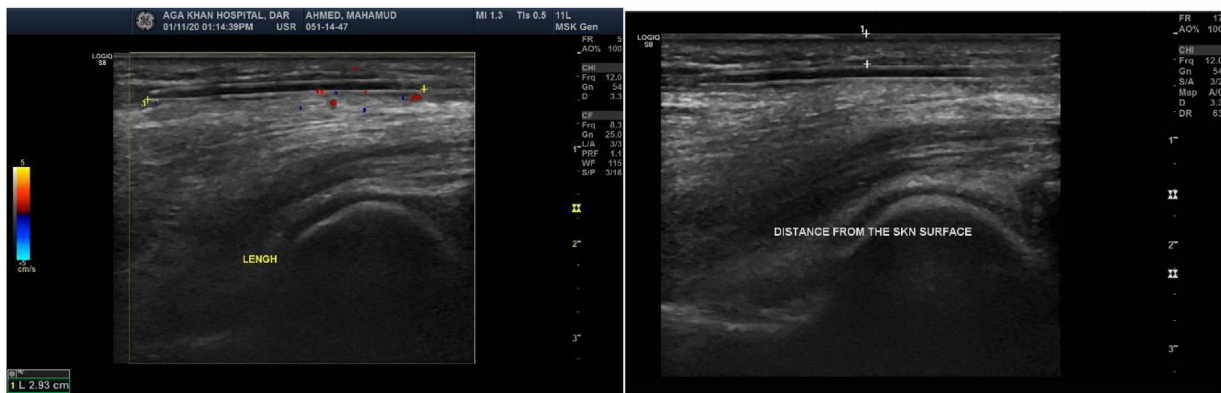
Ultrasound Images of Cannula Fragments.
